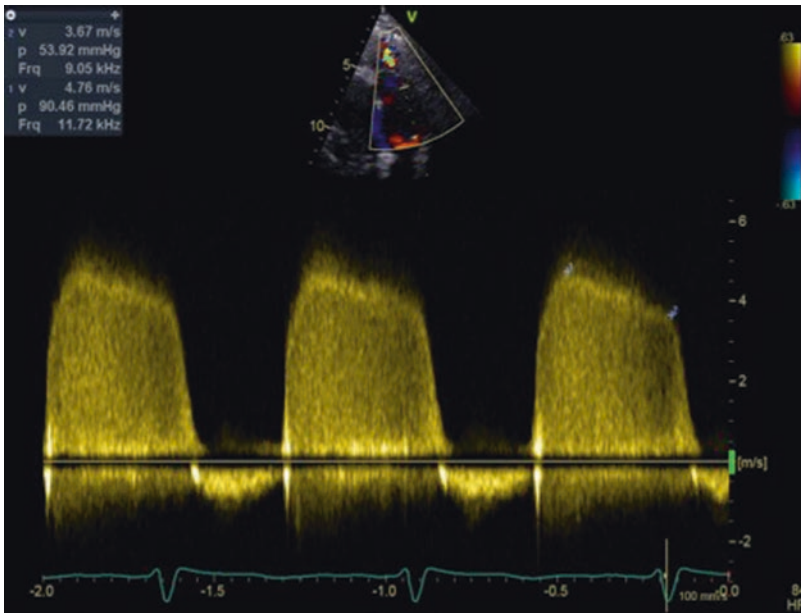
Transthoracic echocardiography, parasternal short axis view, continuous-wave Doppler examination at the level of pulmonary valve: an early diastolic pulmonary regurgitation velocity of 3.67 m/s is measured, allowing an estimation of mean PAP of 96 mmHg and diastolic PAP of 59 mmHg
